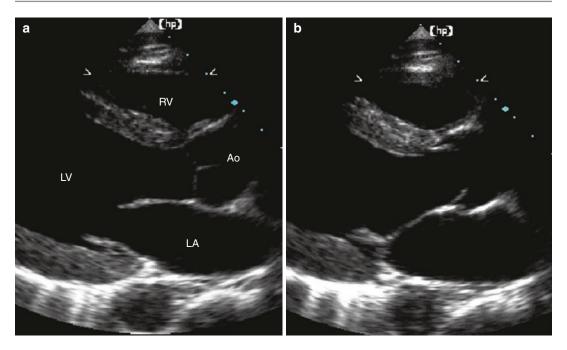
The parasternal long-axis view in (a) diastole and (b) systole are seen in a normal patient. The anatomic chambers are labeled in (a)
